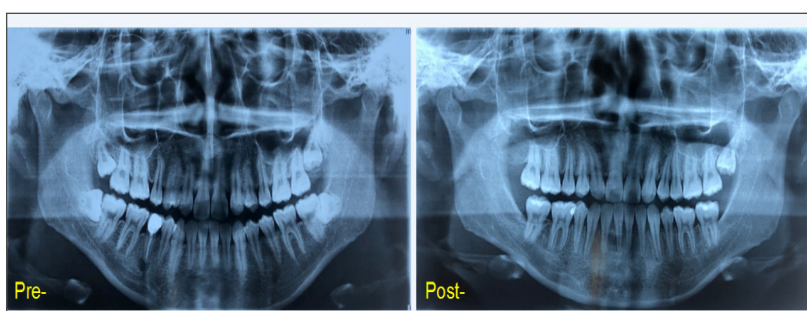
Pre- revealed lateral incisors missing and periapical inflammation. Post- revealed good root parallelism achieved without root resorption.
